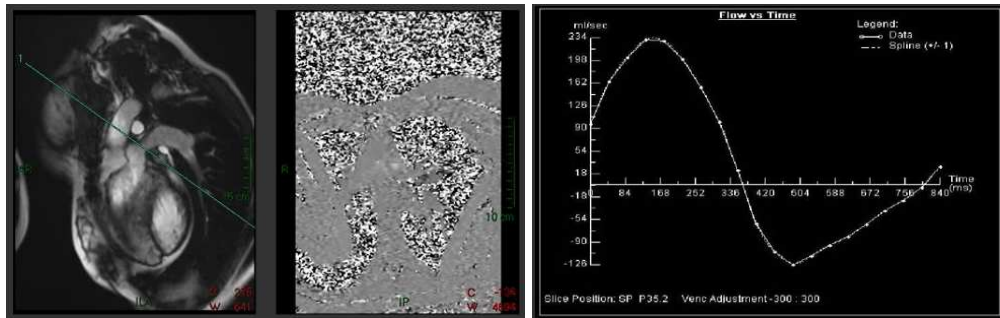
Quantitative 1D measures of blood flow from cardiac MRI.
